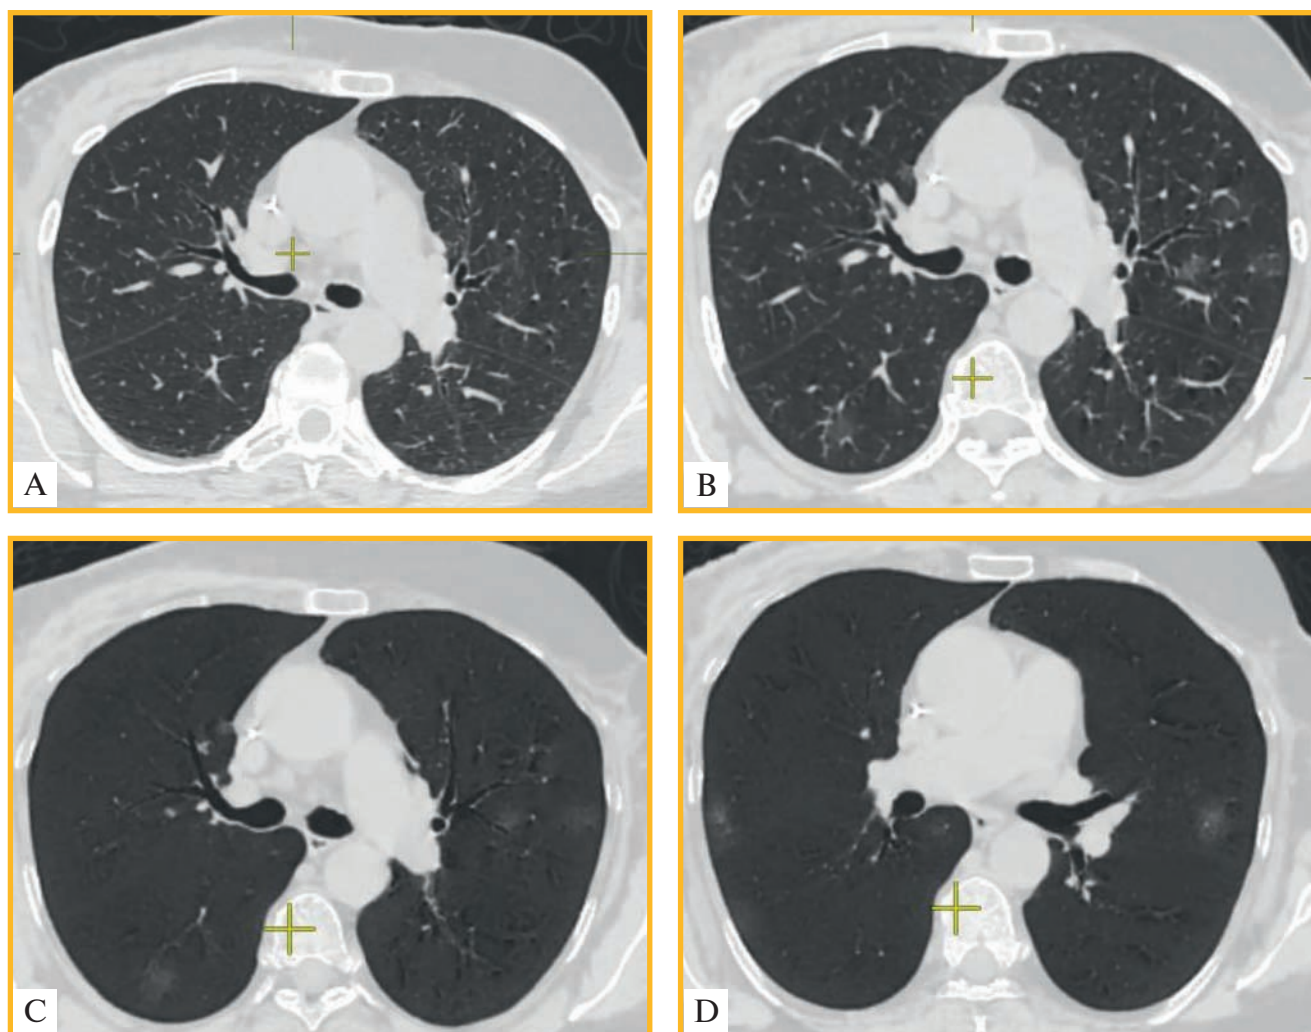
Chest multispiral computed tomography, 1 mm axial slices: A, Day 2 of COVID-19 clinical symptoms, no findings that suggest pneumonia; B, The same patient on day 4 of COVID-19 clinical symptoms. The ground glass opacities appeared in both lungs; C, D, A clearer visualization of the findings in MinIP mode. COVID-19 pneumonia
